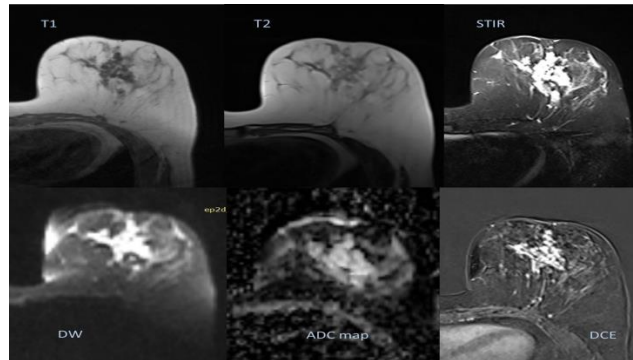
Case 1: MRI of the left breast shows retro areolar mass of low signal intensity on T1 and intermediate signal on T2 weighted images, high signal intensity on STIR, DWI shows high signal intensity and intermediate signal intensity on ADC map with ADC value of $1.38 \times 10^{-3} \text{ mm}^2 / \text{s}$. MR subtraction sequence shows suspicious heterogeneously enhancing left retro areolar lesion.
